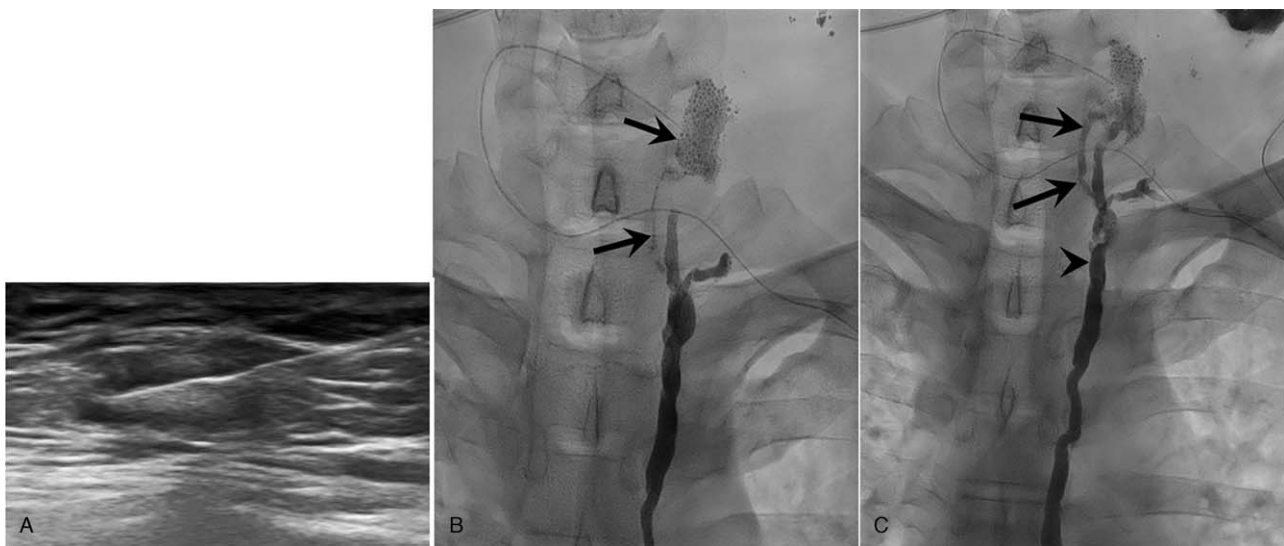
(A) Ultrasonographic-guided inguinal node puncture for lymphatic embolization. Ultrasonographic image shows the access of the inguinal lymph node with a needle. (B) Thoracic duct lymphangiogram before lymphatic embolization. Contrast leakage was demonstrated in the left lower neck (arrows). (C) Thoracic duct lymphangiogram after lymphatic embolization. Lymphatic embolization was performed using a mixture of glue and Lipiodol in the leakage site (arrows) and distal thoracic duct (arrowhead).
